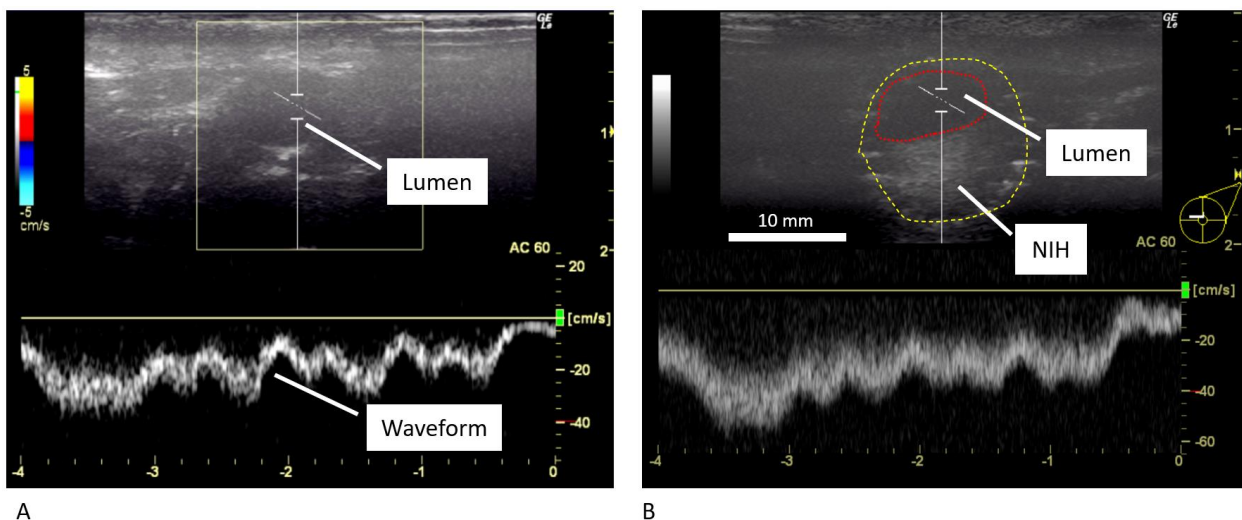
Doppler ultrasound showing blood vessel cross-section and blood flow velocity waveform with respect to time (x-axis). A: control blood vessel (no stent) B: with stent (brighter circular-shape region) and neointimal hyperplasia (NIH) region.
